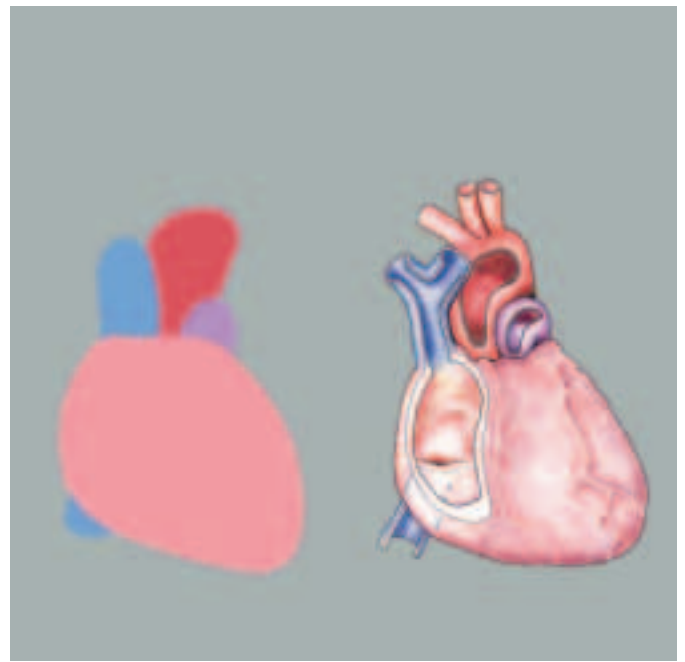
Scheme of x-ray image (left) and anatomical view of the heart (right)
